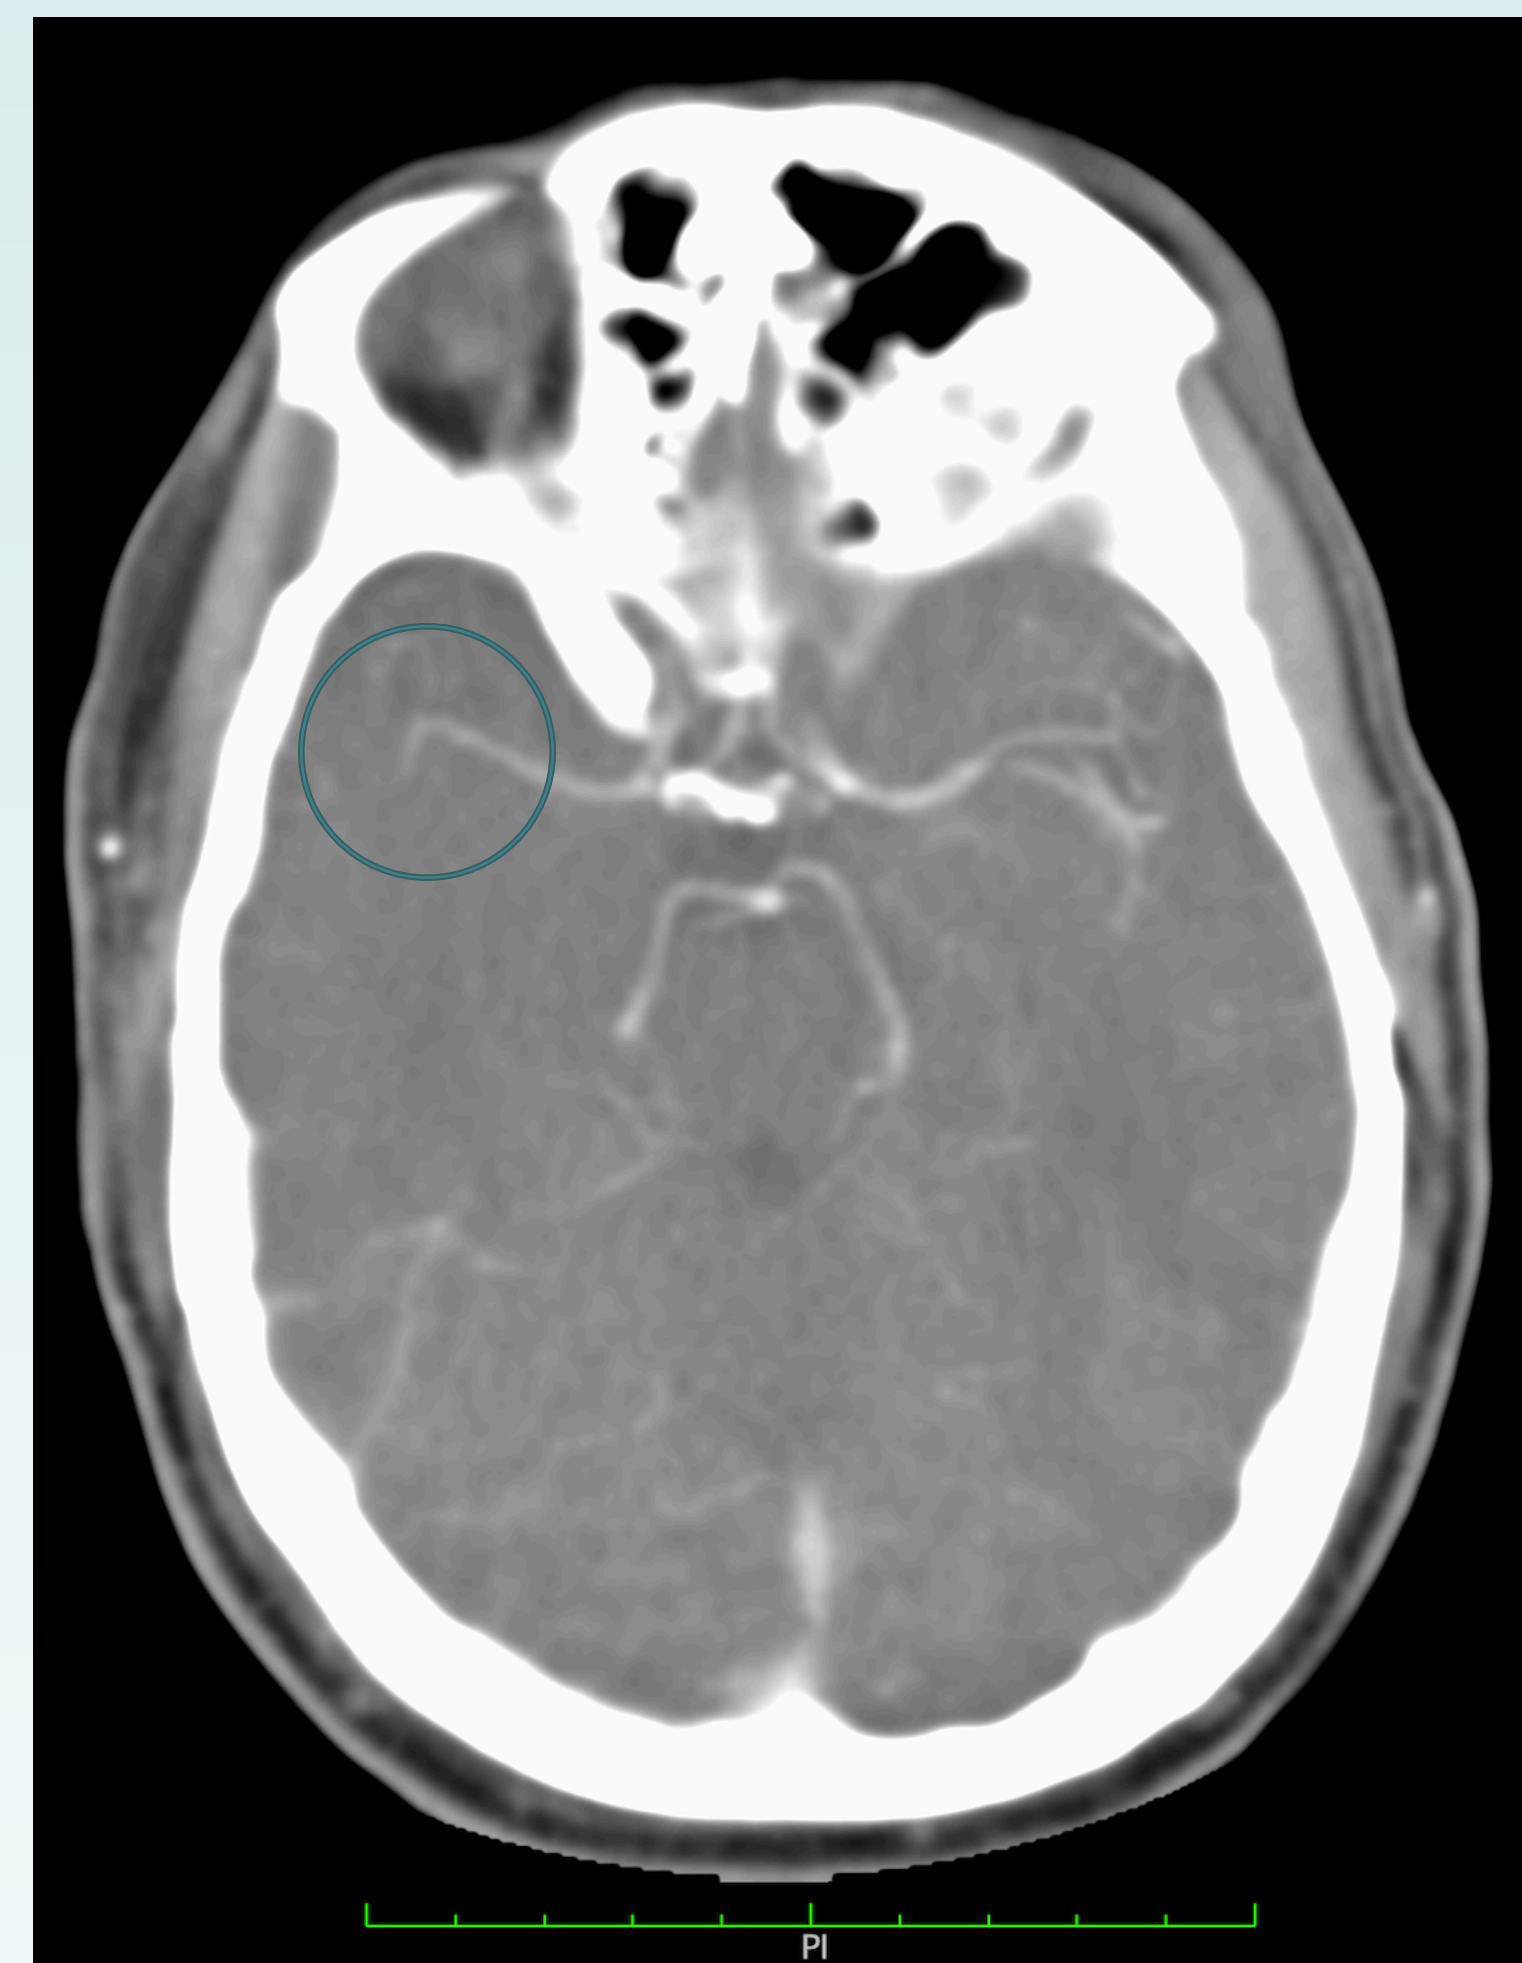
CT angiogram showing occlusion of the M2 segment of the right MCA
